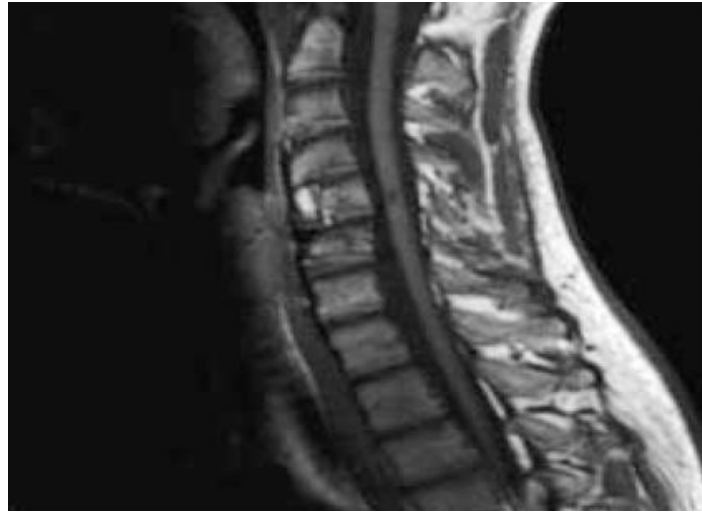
The region of hyperintense signal within the spinal cord of the T2-weighted image (light) indicates nonhemorrhagic spinal cord damage
